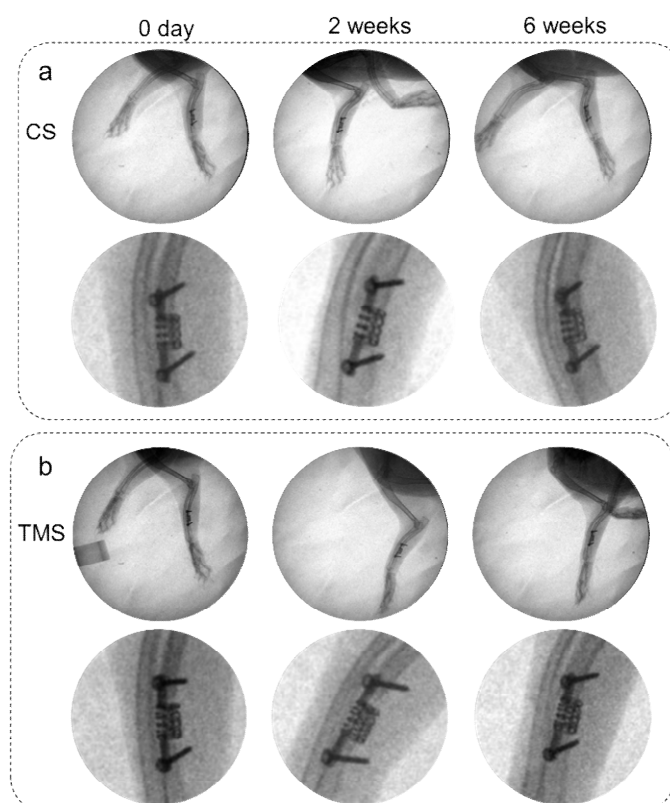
X-ray images of implanted CS and TMS at 0, 2 and 6 weeks. a CS. b TMS.
